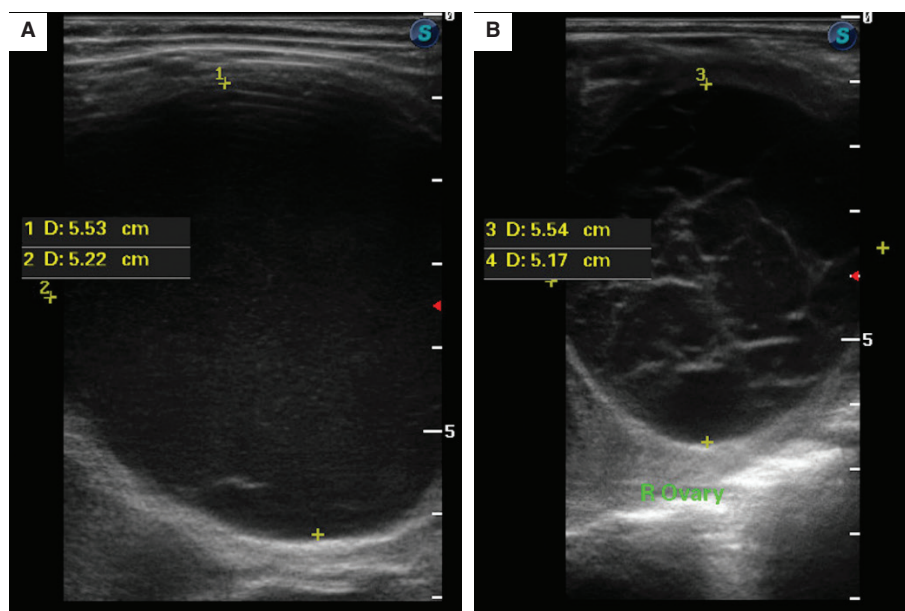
Transrectal ultrasonographic images of left (A) and right (B) ovaries 10 weeks after manual termination of pregnancy (note the decrease in ovarian size)
